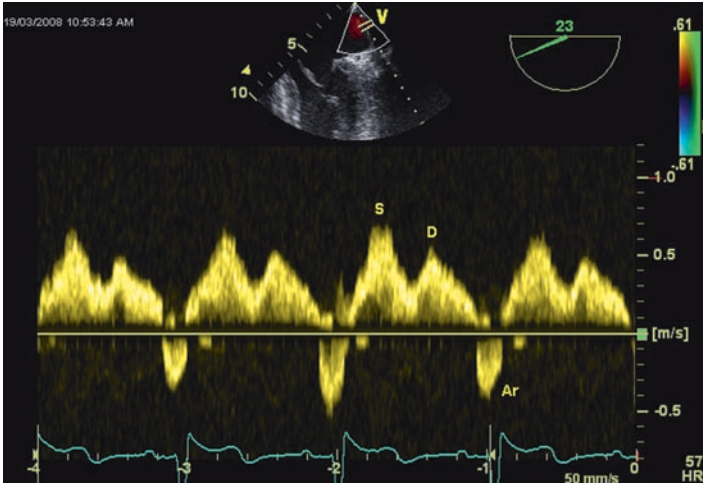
Pulsed wave Doppler of pulmonary vein flow demonstrating systolic (S) and early diastolic (D) forward flow followed by reversed flow during atrial systole (Ar).
